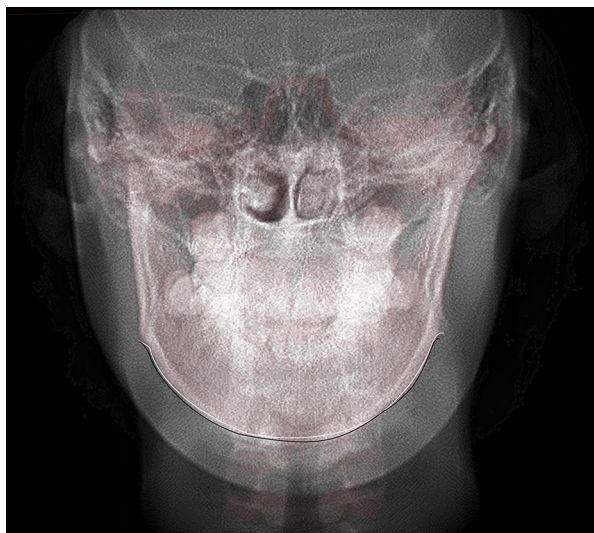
Superimposed 3-dimensional CBCT images showing a slight mandibular deviation. *White line*, Pretreatment; *black line*, 30 months posttreatment.
